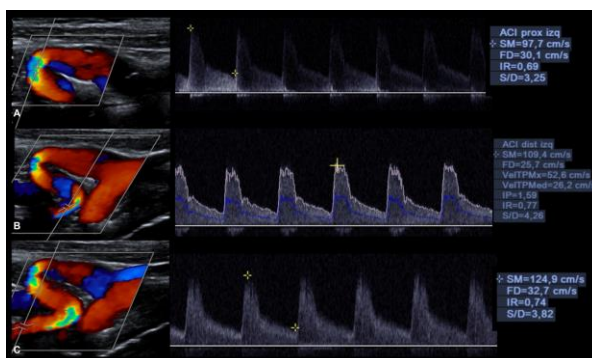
45-years old men with cephalgia. ICA with color and pulsed Doppler application. Assessment of the ICA before angulation (A), After the first angulation (B), and after the second angulation (C). A progressive increase in speed is identified up to maximum velocities of 124.9 cm / s, reaching upper limits within normality.
